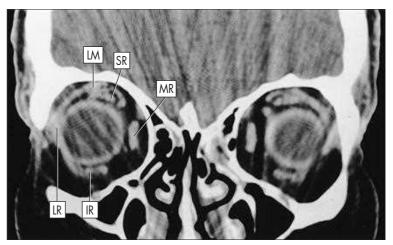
Coronal CT Scan Through the Anterior Portion of the Orbit. The globes are cut in cross-section, and the rectus muscles are seen as flattened densities near the sclera. *IR*, Inferior rectus; *LM*, levator muscle; *LR*, lateral rectus; *MR*, medial rectus; *SR*, superior rectus.
